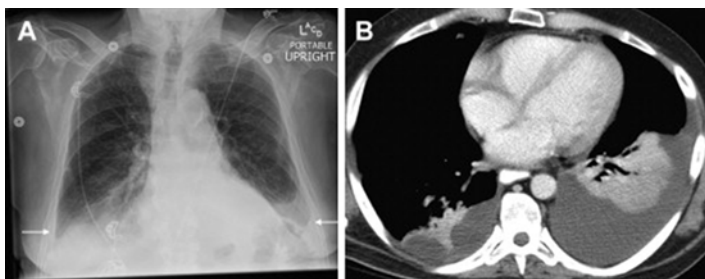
Pleural effusion. (a) AP chest radiograph shows blunting of the costophrenic angles and a small amount of fluid tracking up the pleural space laterally (*arrows*), indicating bilateral pleural effusions. (b) Axial CT image confirms moderate left and small right pleural effusions, with adjacent atelectasis (Reprinted from Bentz and Primack [11], with permission from Elsevier)
